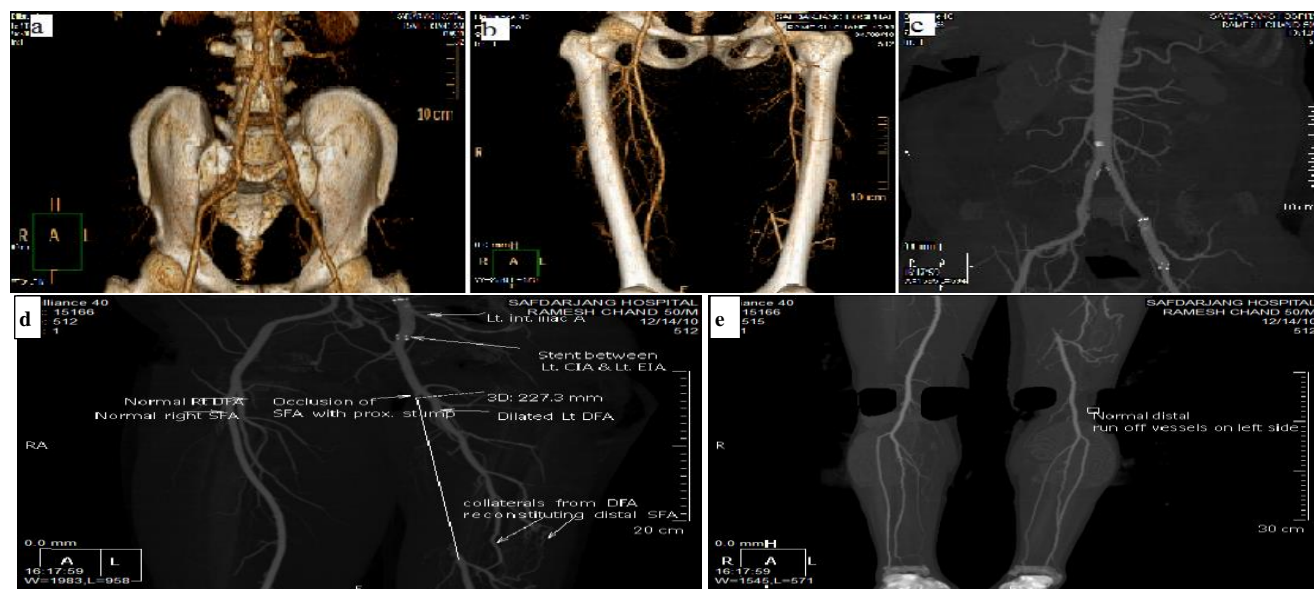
50 year old male presented with left lower limb claudication with pain free walking distance of <200 meters (stage IIb PAOD). 3a) shows single short segment stenosis (<3 cm) of left external iliac artery (TASC type A aortoiliac lesion) with post stenotic dilatation. Abdominal aorta and its branches were normal in this patient. 3b) shows total occlusion of left superficial femoral artery of > 20 cm (TASC type D femoro popliteal lesion) with reconstitution of popliteal artery by the collaterals from dilated ipsilateral DFA. 3c & 3d) shows post stenting CT angiography images in MIP reconstruction. 3e) shows normal run off in leg vessels.
